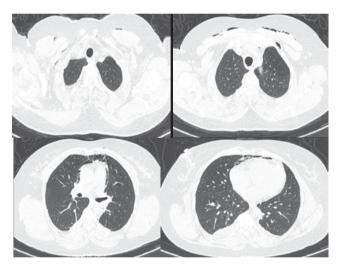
HRCT chest done on day 6 of admission showing almost complete resolution
